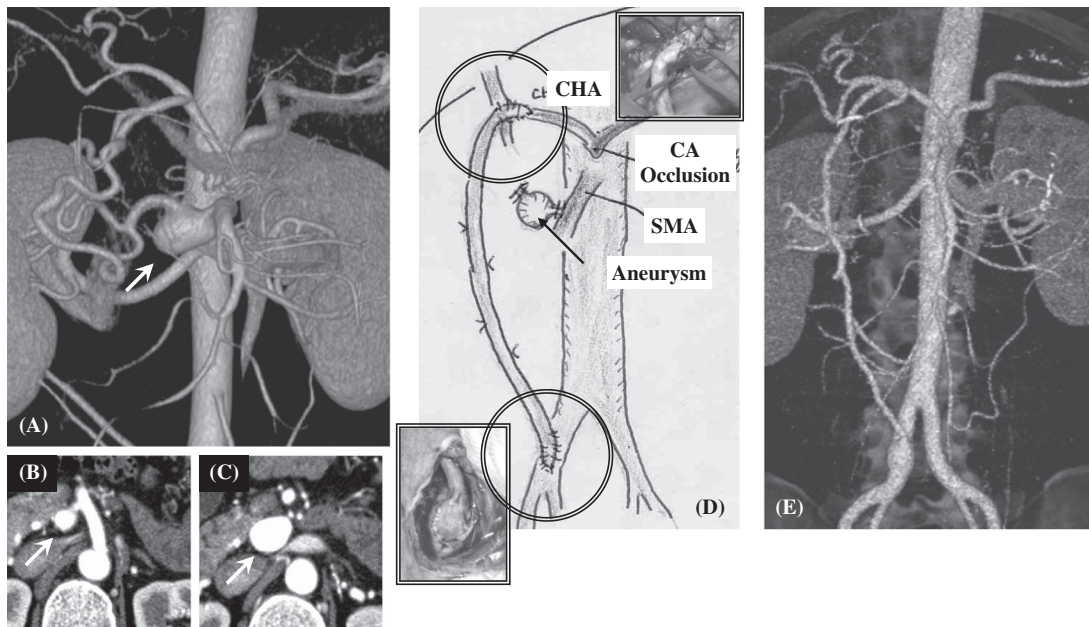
Computed tomography (CT) scan shows the inferior pancreaticoduodenal artery aneurysm (IPDAA) near the trunk of the superior mesenteric artery (A–C; arrow). The right common iliac artery to the common hepatic artery bypass was performed after aneurysmectomy (D). Three-dimensional CT performed 15 months after surgery reveals the patency of the graft and disappearance of the pancreaticoduodenal arcade (E) (Case 5).
